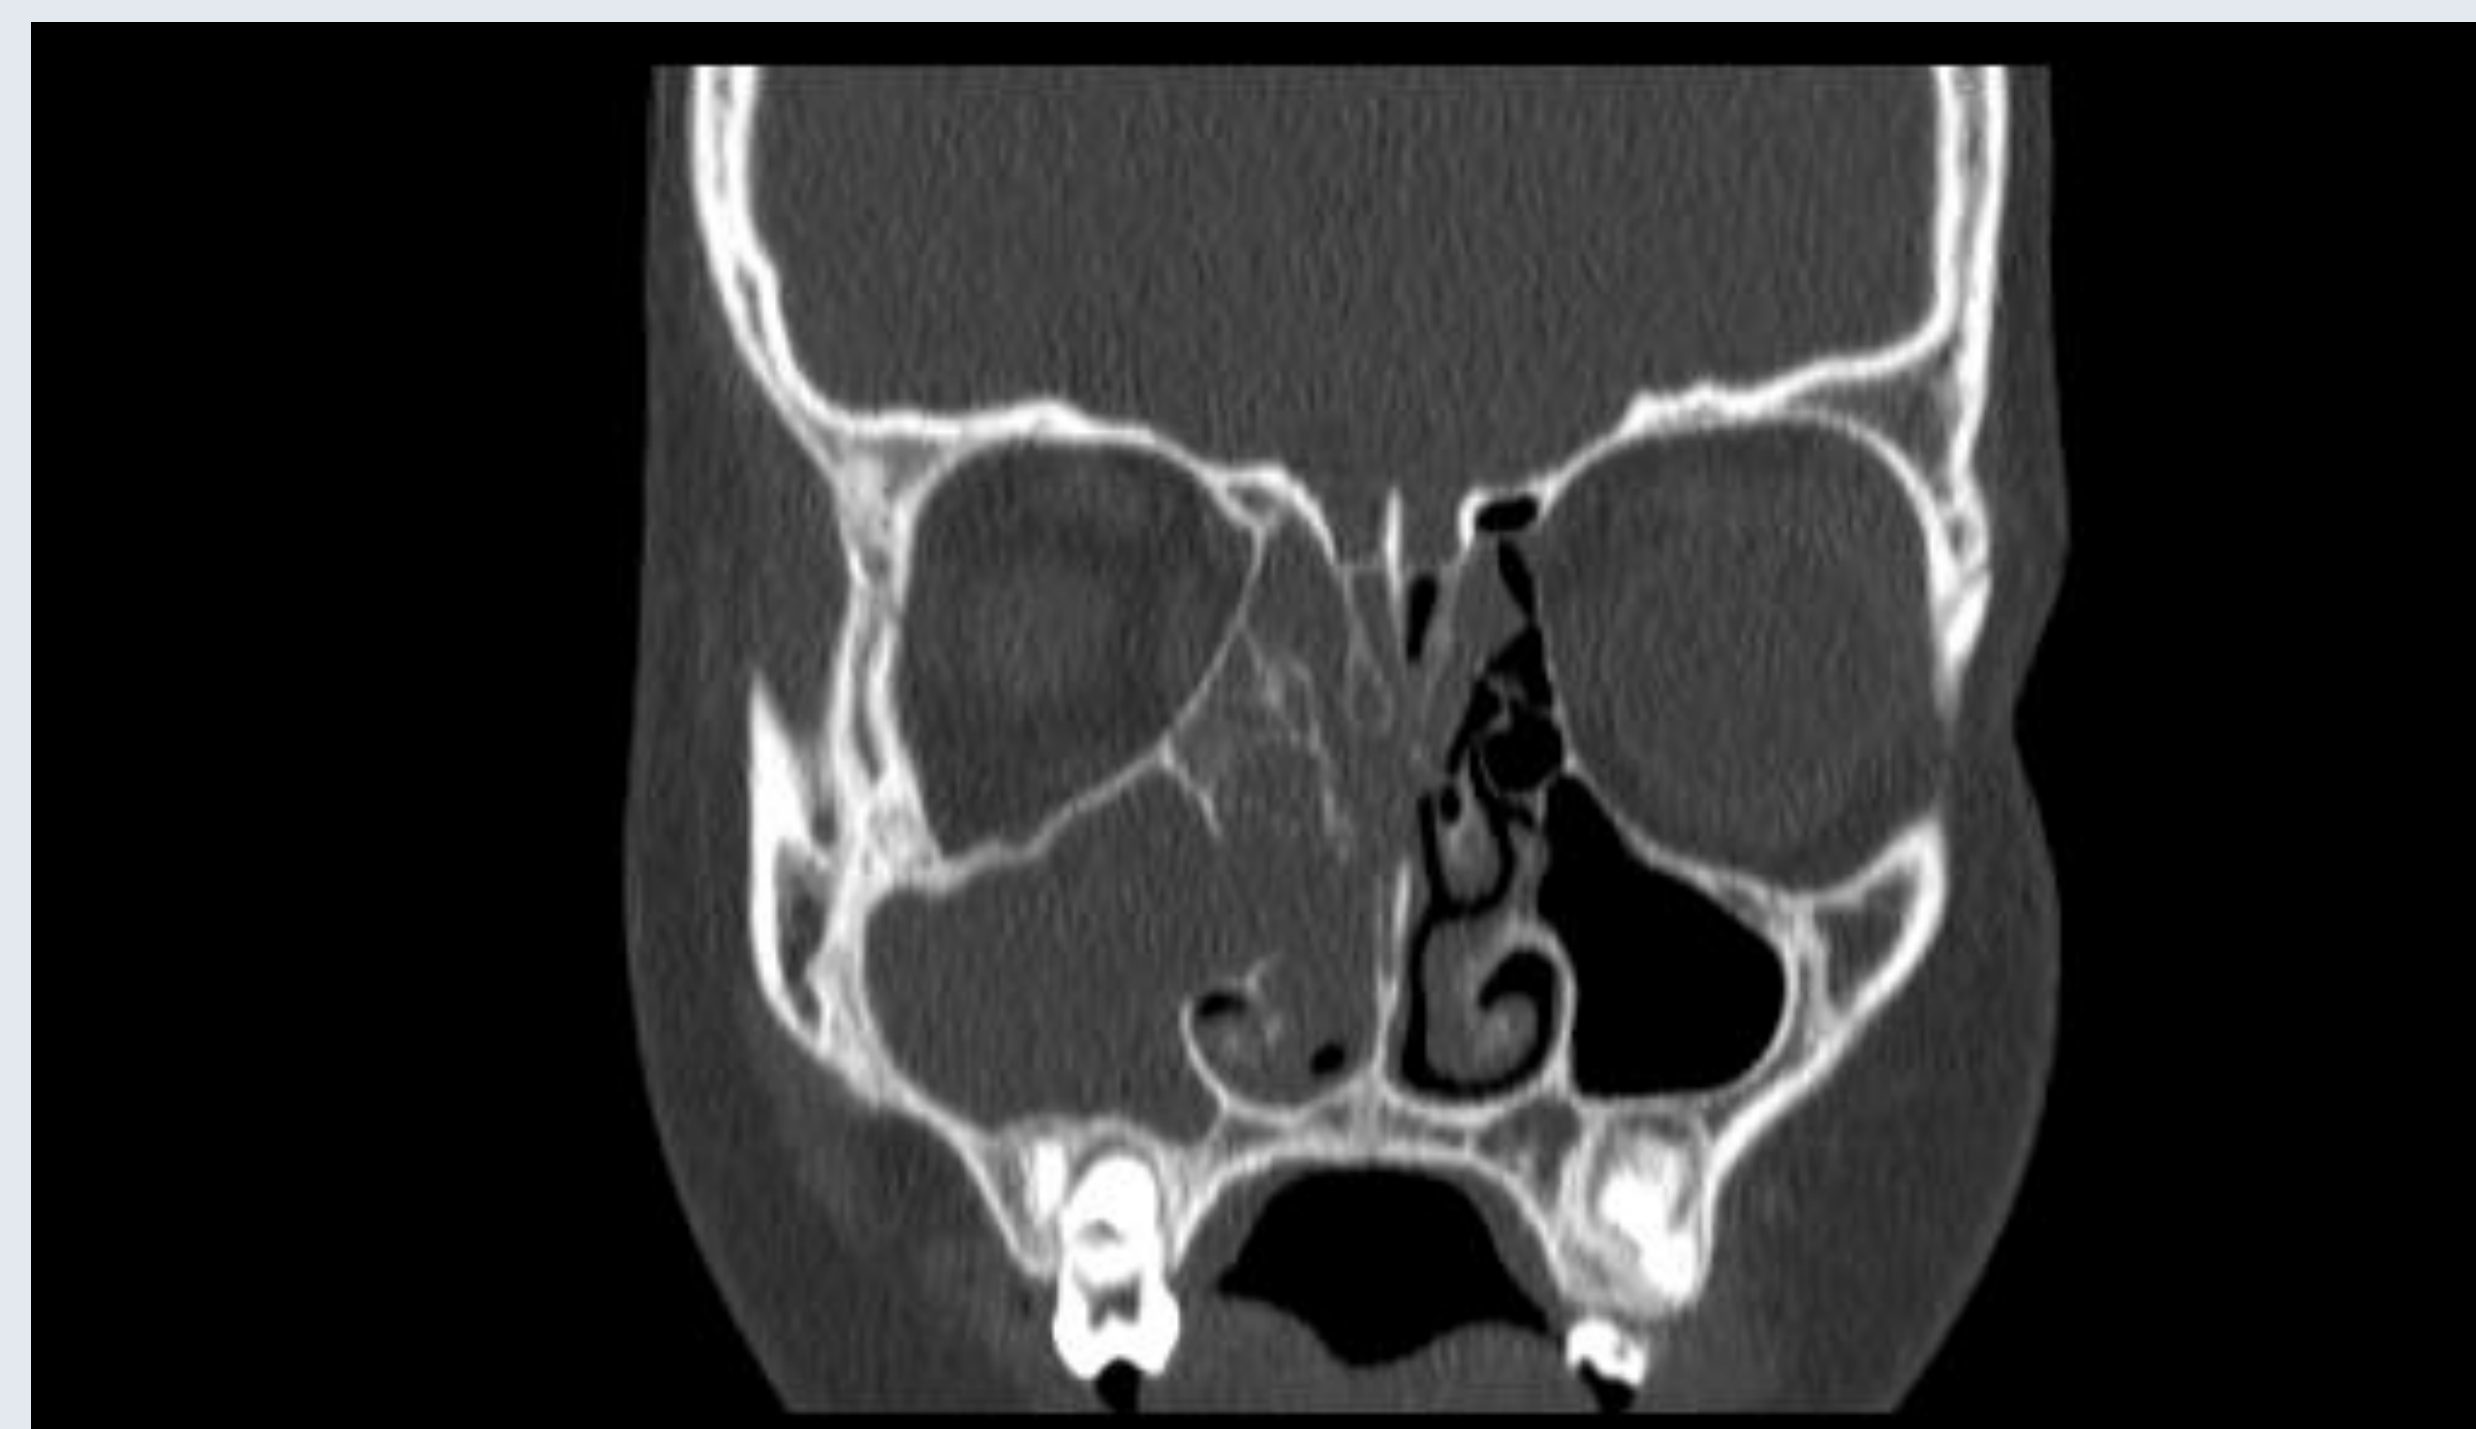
Coronal CT Sinus demonstrating pan-opacification in the right sinonasal cavities.
